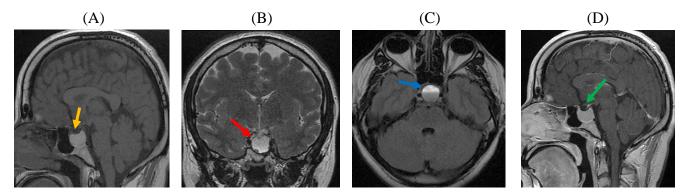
Pituitary MRI in sagittal T1-weighted imaging (A), coronal T2-weighted (B), Flair (C), sagittal T1 after Gadolinium injection (D): showing an intra-sellar pituitary lesion, described as hyperintense on T1 (yellow arrow), T2 (red arrow), and Flair, demonstrating a fluid-fluid level (blue arrow), with late and peripheral enhancement post-contrast (green arrow), The lesion shows compression of the optical chiasm, downward displacement of the sellar floor, and upward displacement of the pituitary stalk, while supporting the permeability of the cavernous sinuses and lateral internal carotid arteries consistent with a pituitary macroadenoma in apoplexy. (Department of Radiology, Hassan II University Hospital Center, Fez, Morocco)
